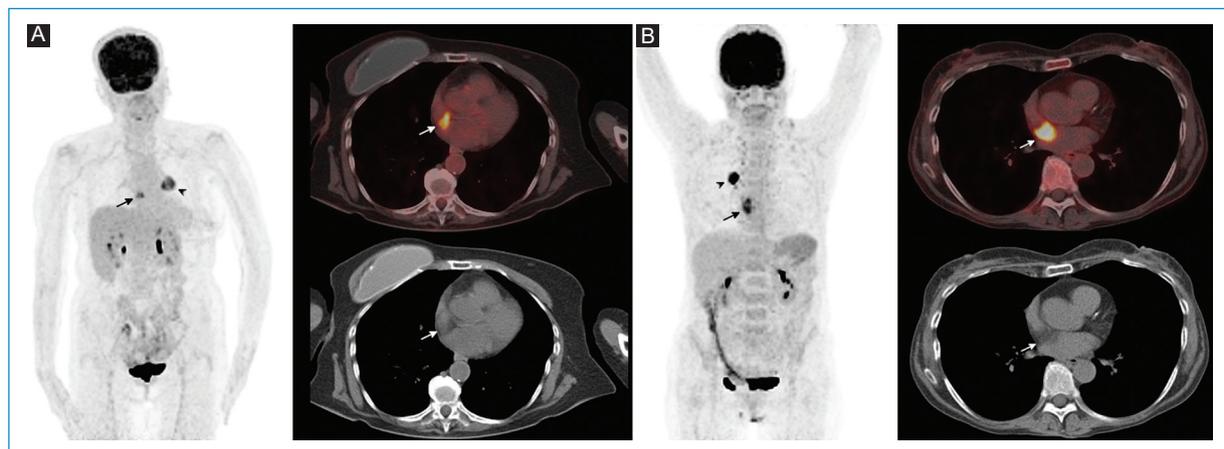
A: MIP and axial slices of 18F-FDG PET-CT performed to 69-year-old female under study because left lung mass (arrow-head). B: MIP and axial slices of 18F-FDG PET-CT to 54-year-old female in study because a solitary pulmonary nodule (arrow-head). Both cases revealed LHIS with high metabolic rate (arrows, SUV_{máx}: 6.8 and 8.9, respectively).
